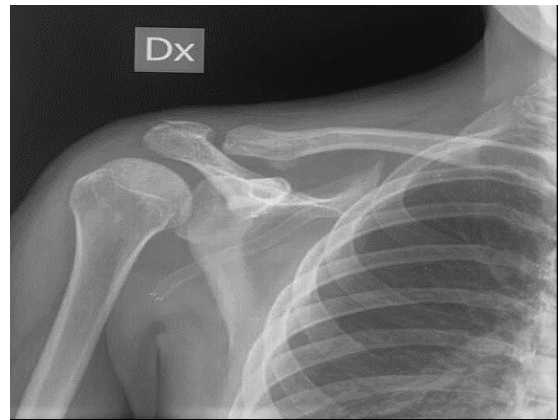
Postoperative X-rays after 5-week removal of K wires.
